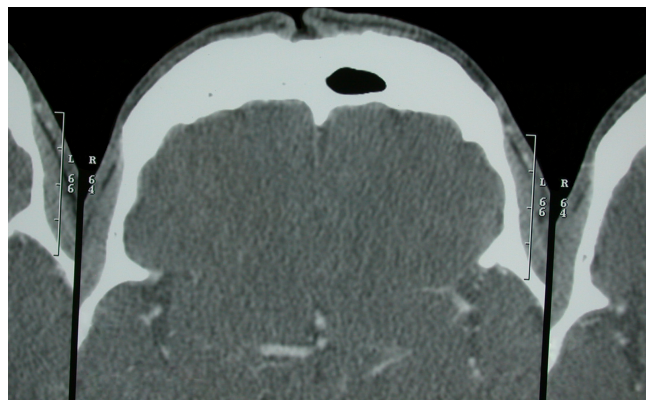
Computed tomographic image showing a blind-ended frontal sinus fistula.
